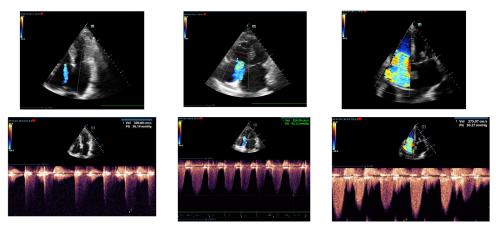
c.9. Mild, moderate and severe tricuspid regurgitation (upper row: color Doppler, 4-chambers view and bottom row: CW Doppler, 4-chambers view)
